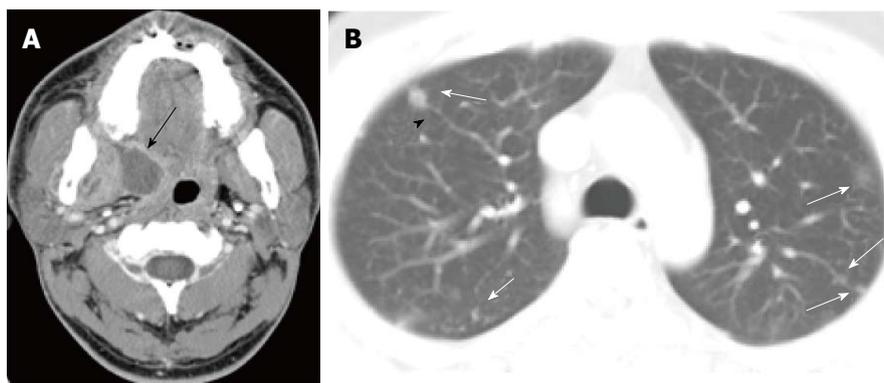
Pulmonary septic emboli from paratonsillar abscess in a man in his 20s. A: Enhanced computed tomography (CT) at the level of oropharynx shows an abscess at the right paratonsillar region (arrow); B: Chest CT with a 5 mm slice thickness reveals small nodules in both lungs (arrows), some of which are in contact with the periphery of pulmonary vessels (arrow head).
